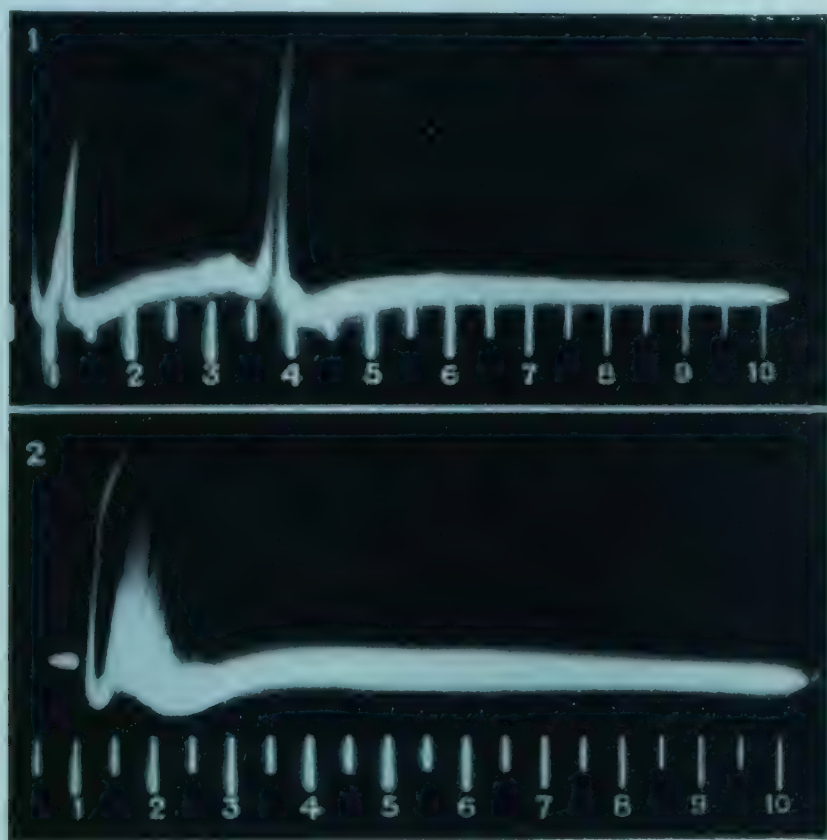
Ultrasonic 'echo sounding' technique; simple display of the transmitted and reflected pulses. The probe was placed over the bladder of a patient with acute retention of urine following colporrhaphy.
